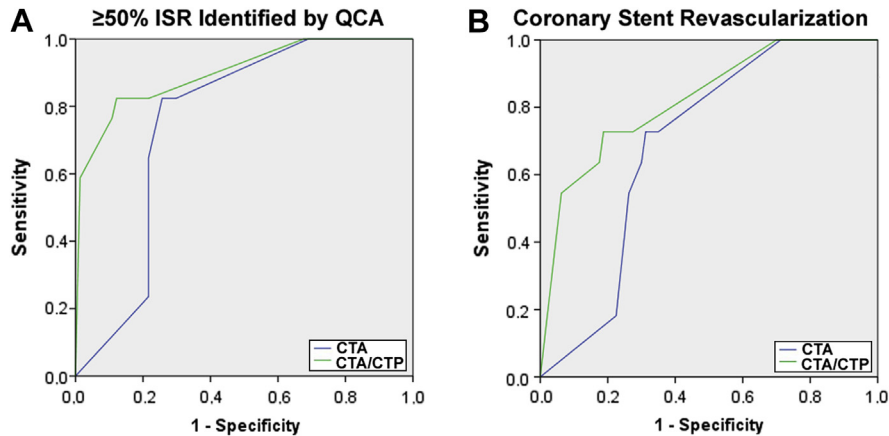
Diagnostic Performance of CTA and Combined CTA/CTP
